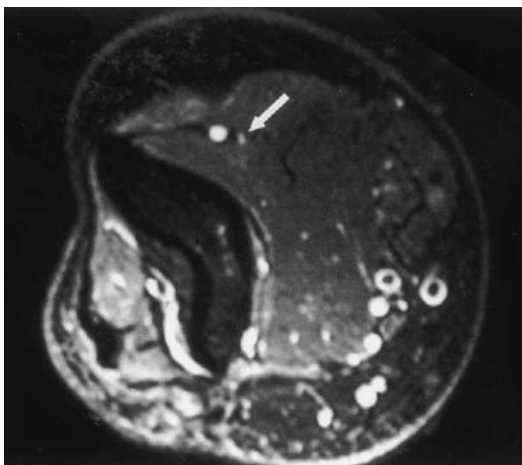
Axial STIR MR image through the proximal forearm of a patient with clinical and electrodiagnostic evidence of a radial neuropathy. Note the increased signal of the radial nerve (white arrow) (from Reference 13).
